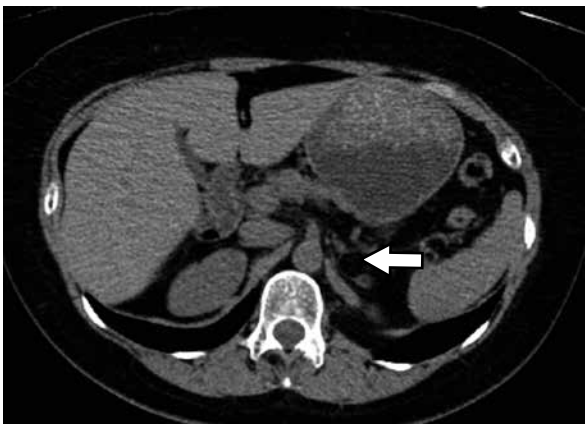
CT. Axial cut: Image with low fat density, well defined, homogeneous located in the left suprarenal gland (arrow) corresponds to lipoma.
